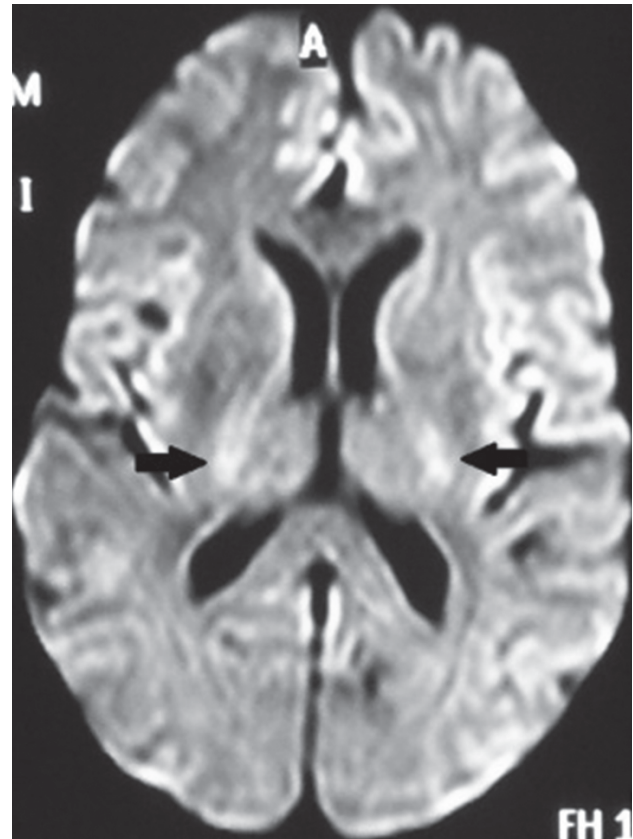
MRI brain FLAIR showing hyperintense foci in subcortical and periventricular (arrows) white matter of both cerebral hemispheres.
